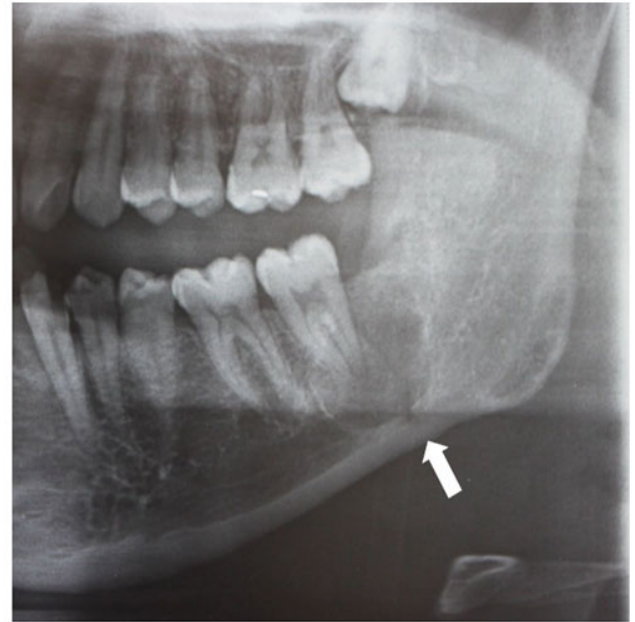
Postoperative panoramic radiograph revealed an obvious bony fracture line from the alveolar crest to the inferior border of left mandible (arrow).
